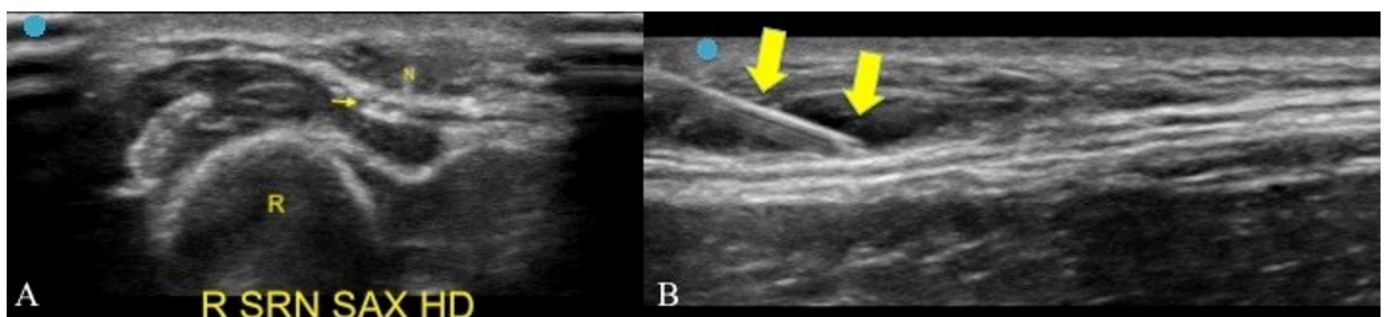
(A) Out-of-plane approach for ultrasound-guided perineural hydrodissection of the superficial radial nerve in transverse axis. R: Radius; N: needle tip. Thin arrow, superficial radial nerve. (B) In-plane approach for ultrasound-guided perineural hydrodissection of the superficial radial nerve in long axis. Thick arrows, needle.
